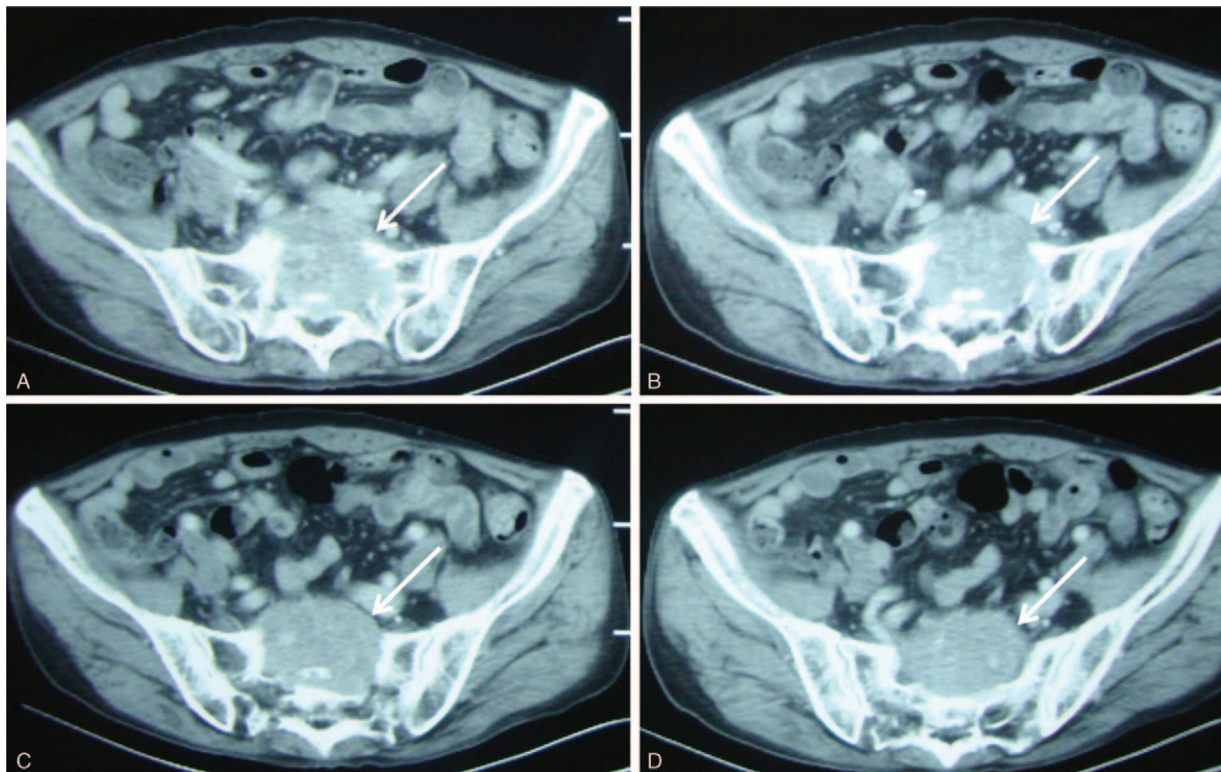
(A–D) Computed tomography revealed destruction of sacrum and spinal cord compressions caused by metastatic malignant pheochromocytoma.
